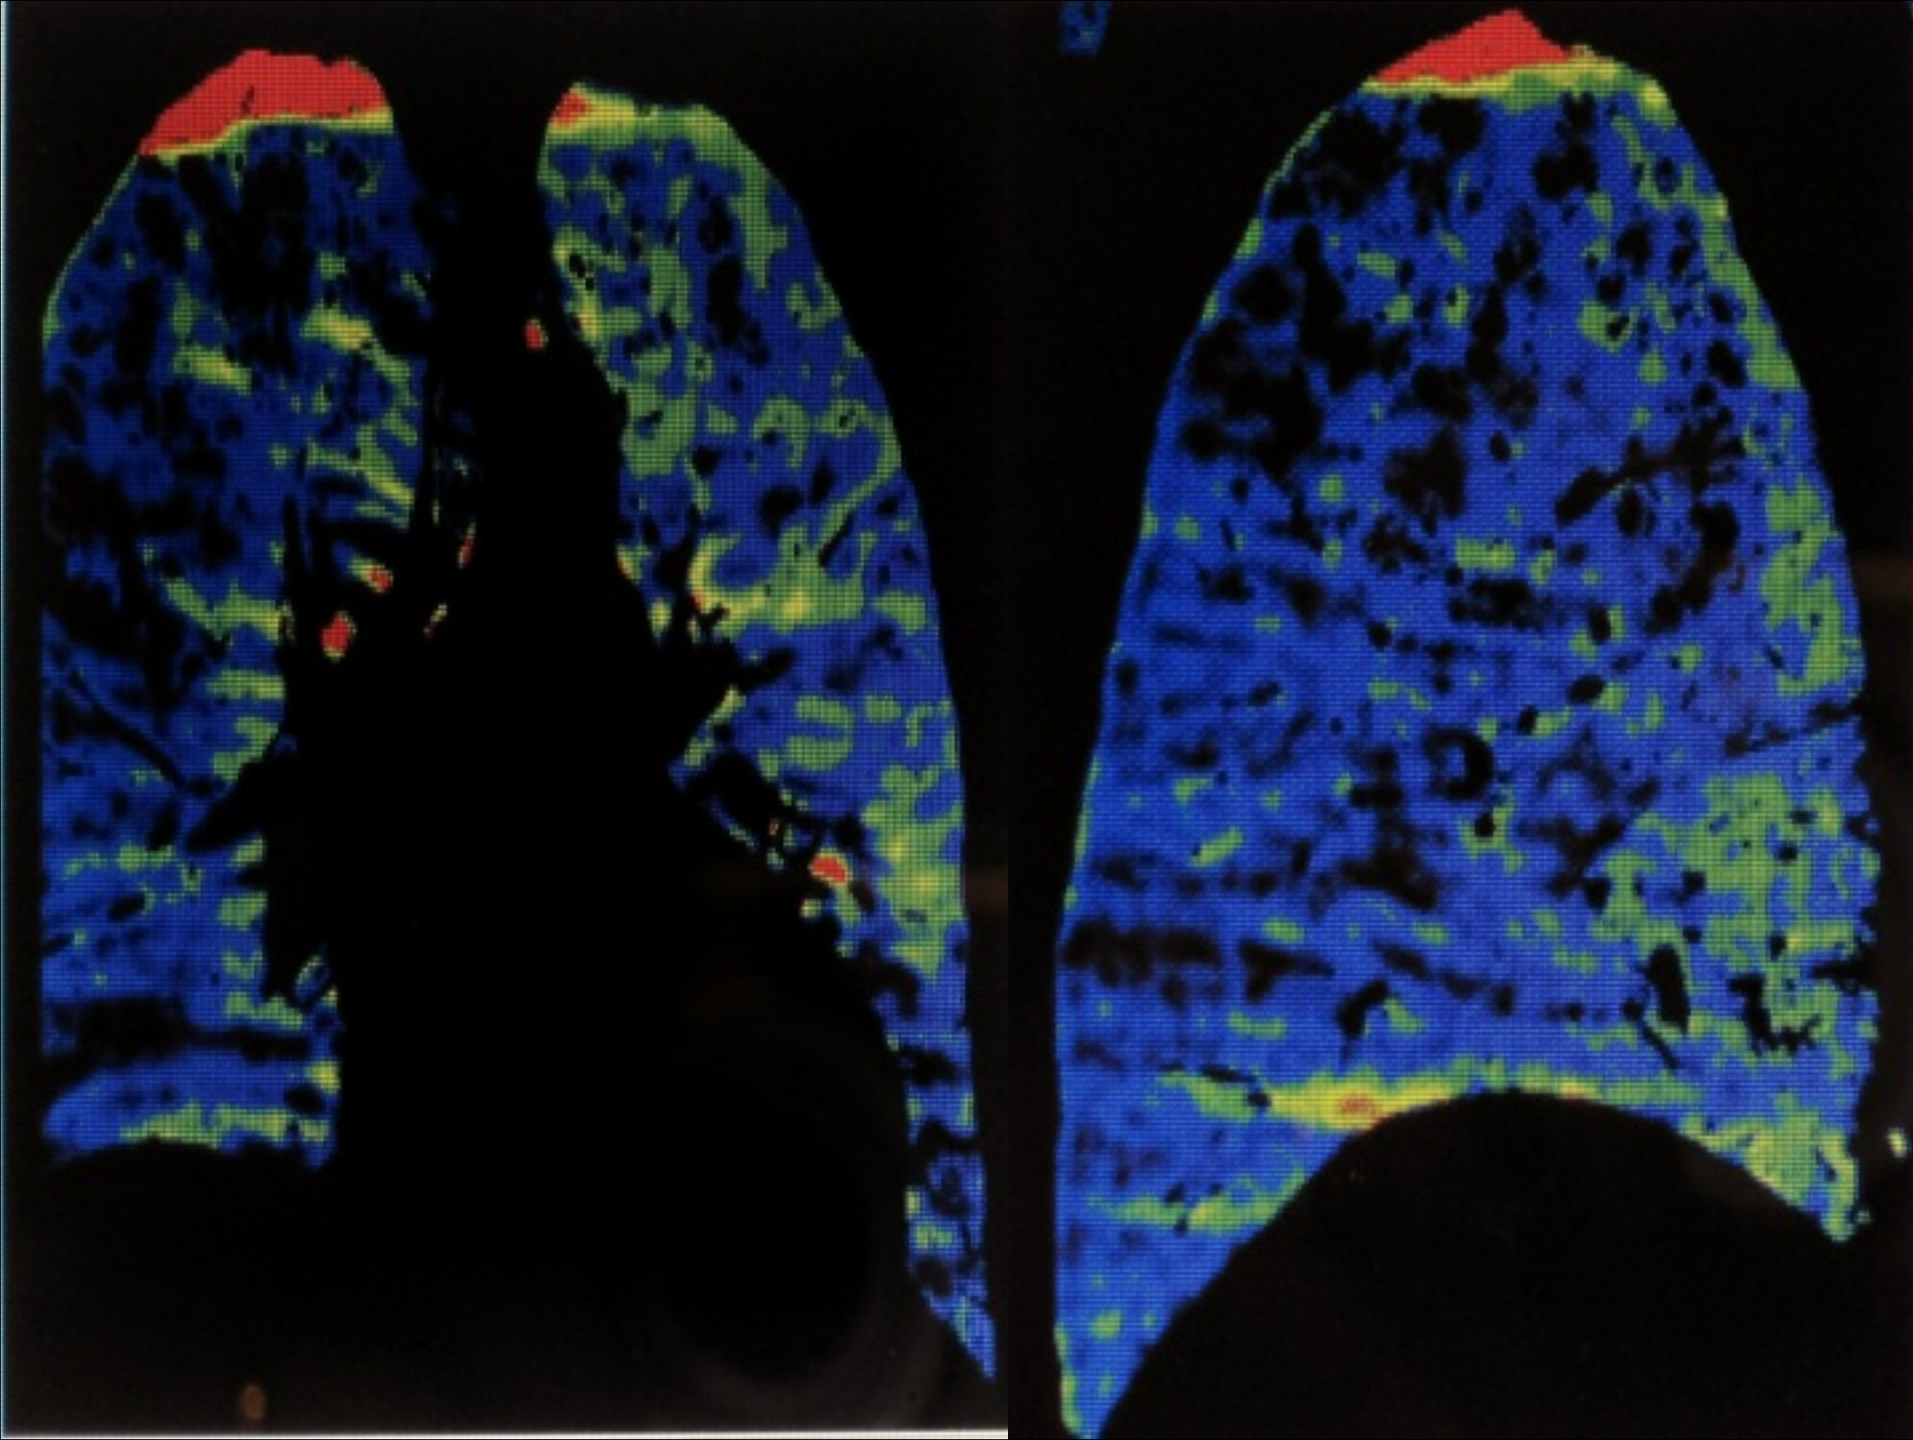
Xenon-enhanced dual-energy CT (DECT) lung ventilation study of 54-year-old man. DECT-based chest CT acquisition was performed while patient inhaled xenon gas.
